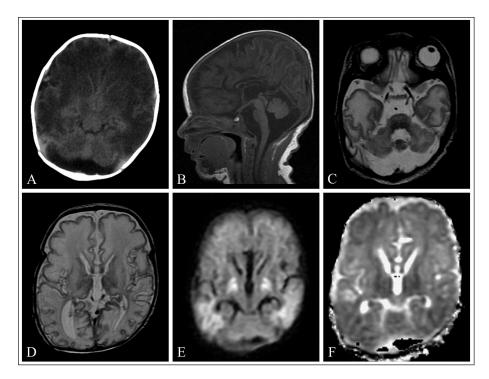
Acute neuroimaging changes. Patient 2 (A) CT of the brain at the age 4 days showing diffuse brain swelling causing effacement of cerebral sulci and compression of the lateral ventricles. Hemispheric white matter and basal ganglia have remarkably low attenuation. Less remarkable low attenuation is evident in the thalami and cerebellum. (B-F) MR images of the brain at age 13 days. (B) Sagittal T1-weighted MR image showing low signal in the hemispheric white matter with relatively bright, thin cortex, extremely thin corpus callosum, and large cisternal magna. (C and D) Axial T2-weighted MR images bilateral and symmetrically abnormally high signal in the hemispheric white matter, basal ganglia, and posterolateral thalami. The cerebellar hemispheres are equally hypoplastic, and less striking high signal changes are seen in the cerebellar white matter. (E) Diffusion-weighted MR image and (F) apparent diffusion coefficient (ADC) map demonstrating symmetric diffusion restriction in basal ganglia, thalami, and occipitotemporal area.
